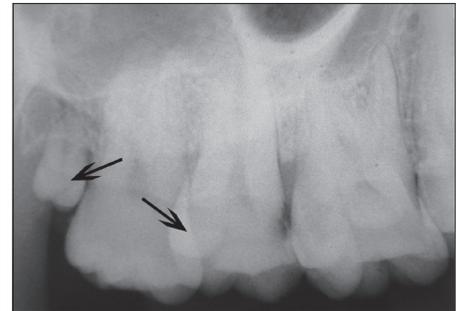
Left side intraoral peri-apical radiograph showing carious maxillary left second molar (27), paramolar and distomolar
